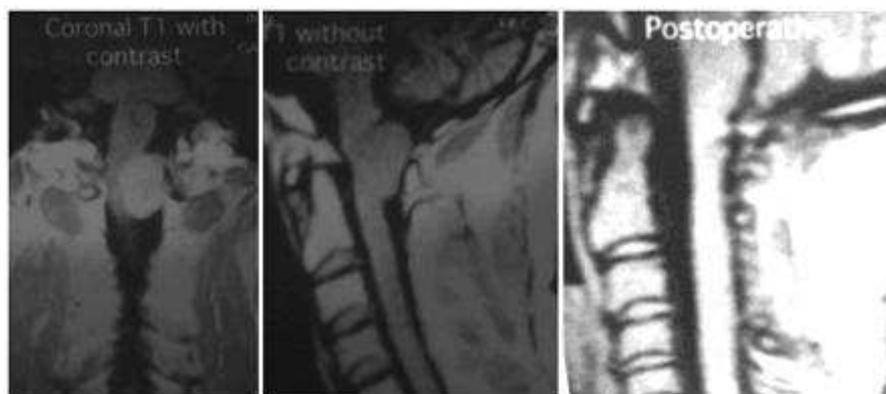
Pre and postoperative MRI of a case of posterior foramen magnum meningioma
